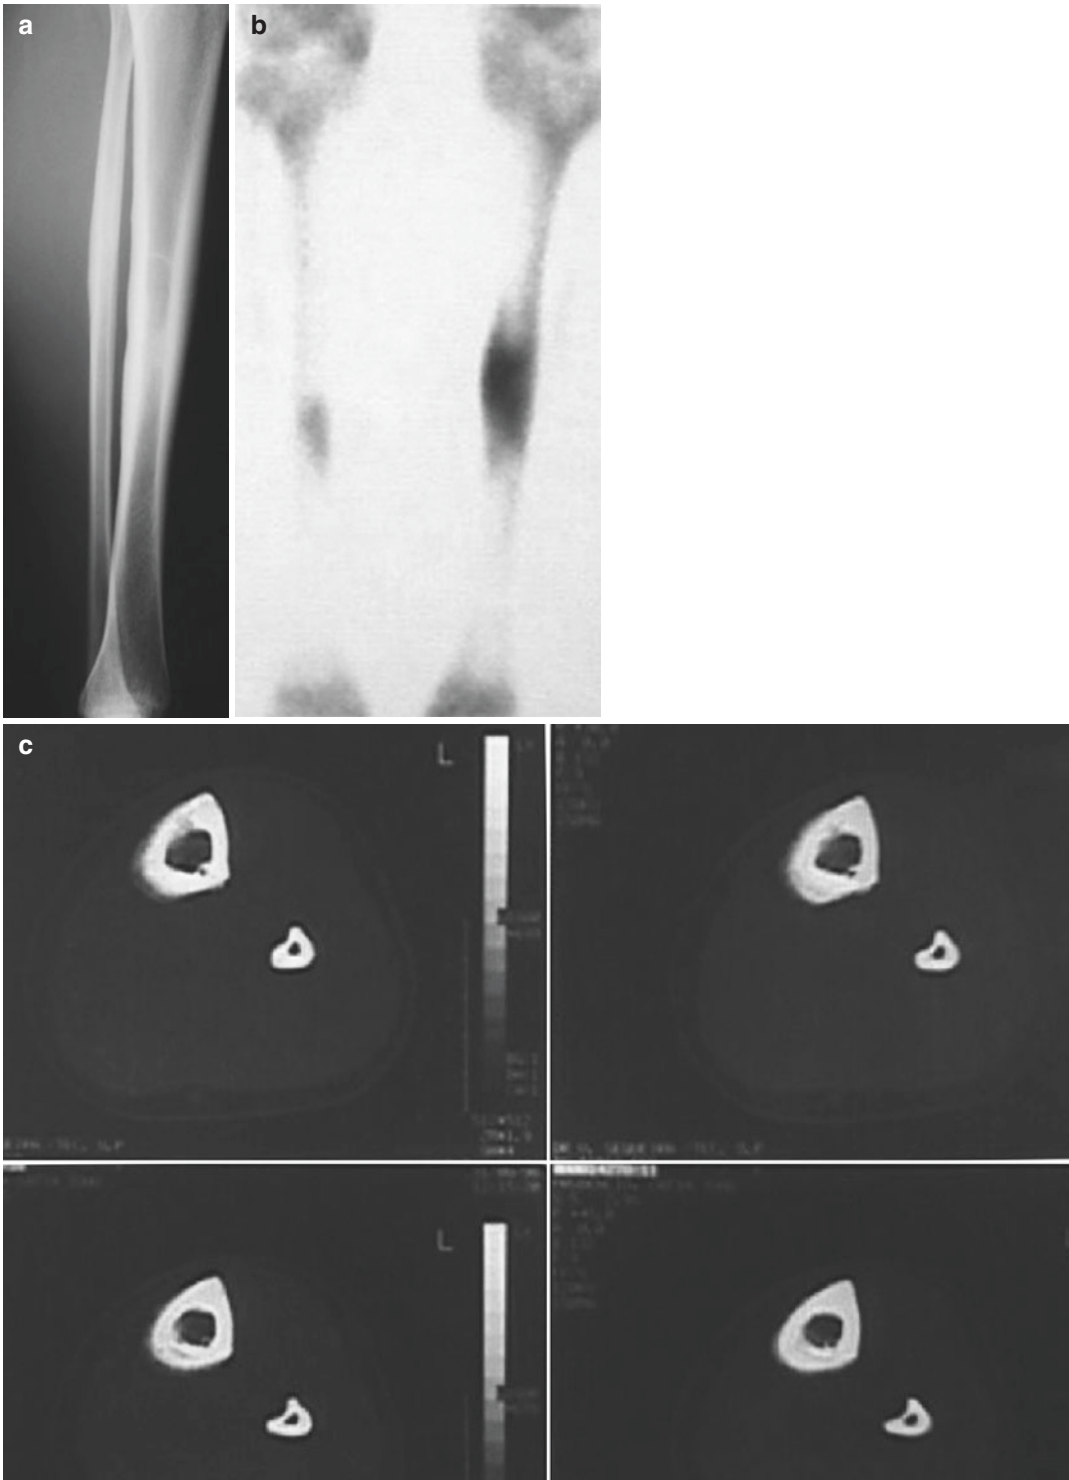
A 21-year-old military with pain in both legs which increase with gait (a), left tibia periostitis with (b) positive scintigraphy, and (c) CT scan bone reaction (Courtesy of Dr. B. Vasconcelos, Lisboa, Portugal)
